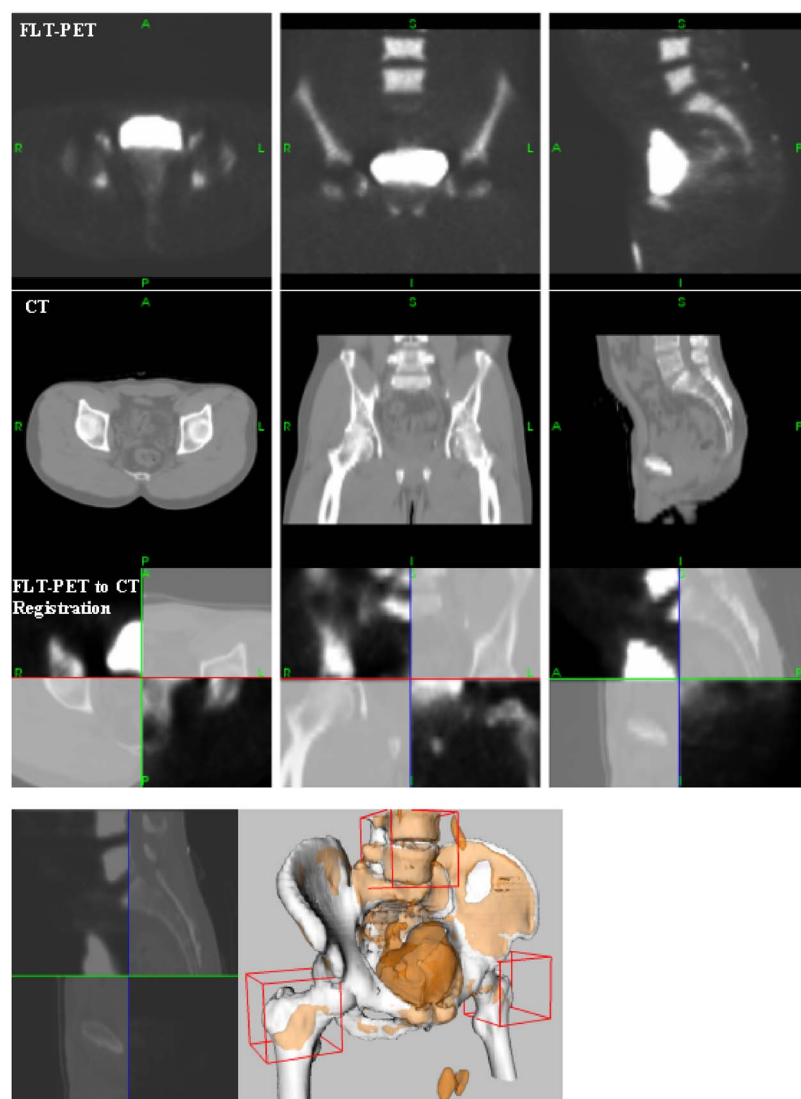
Sagittal, coronal, and axial views of the FLT-PET images (first row) and CT images (second row). The checkerboard of the CT and FLT-PET images after registration is shown in the third row and the left panel of the fourth row. The right panel of the fourth row shows a stereotactic view of the matched PET and CT images after registration.
